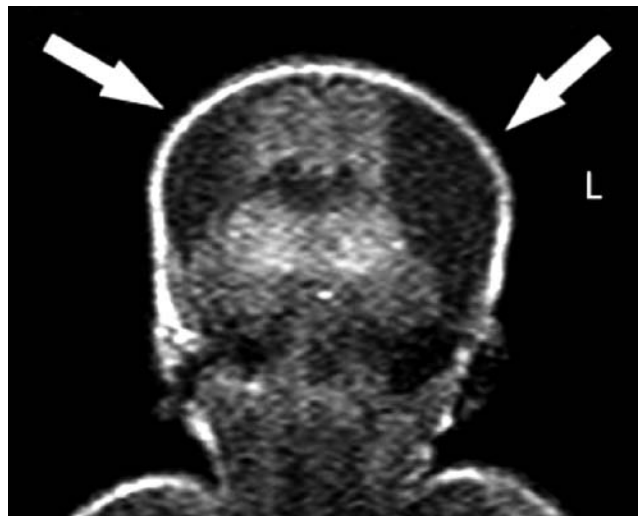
Bilateral parietal clefts (arrows) are demonstrated in the T1 weighted coronal MRI image.
